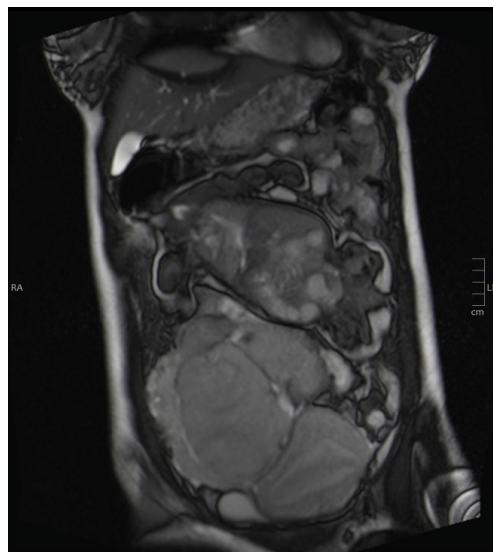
MRI imaging with TRUFFI sequences. Axial plane: Intra-abdominal pregnancy with transverse presentation, absence of peritoneal effusion, and no amniotic fluid and sac detectable.
